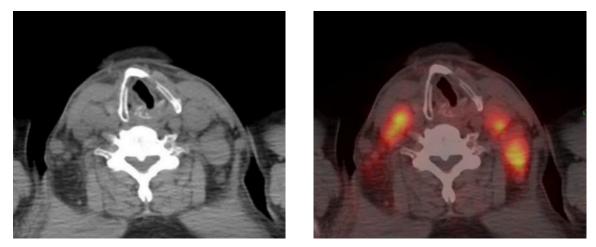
18F-FDG PET/CT performance of patients with Hodgkin's lymphoma (left: CT imaging; right: PET imaging)
